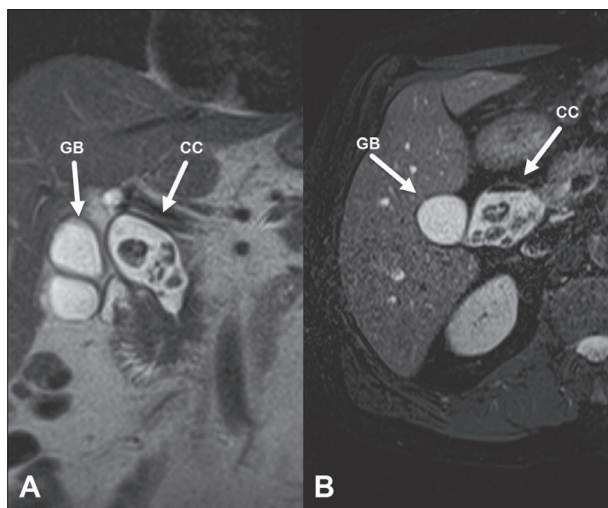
Abdominal magnetic resonance imaging – gallbladder (GB) and Type I choledochal cyst (CC) in sagittal (A) and axial (B) plane
